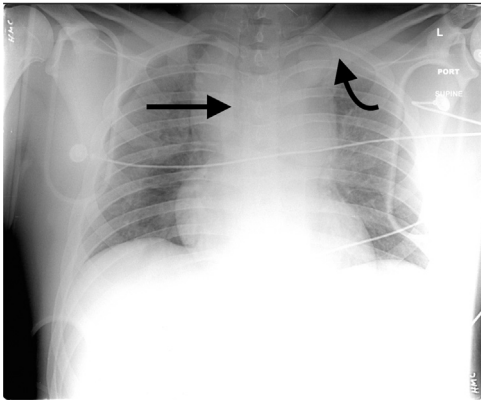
Portable chest radiograph of a patient in a high-speed motor vehicle collision shows radiographic findings of acute traumatic aortic injury. There is abnormal widening of the mediastinum, lack of definition of aortic contour, left apical cap (curved arrow), and deviation of the trachea (arrow). There is also a right pneumothorax. Based on the radiographic appearance CT angiography was emergently performed.
